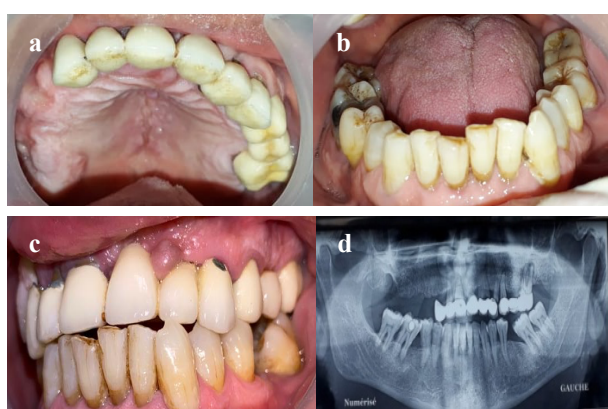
Pre -operative figures; a) Pre-treatment maxillary occlusal view, b) Pre-treatment mandibular occlusal view, c) Occlusal maxillo-mandibular relationship, d) Pre operative panoramic radiograph.
